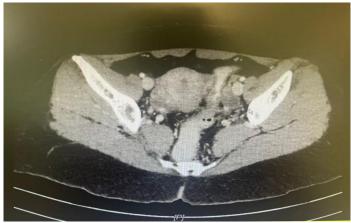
Contrast Enhanced CT scan (CECT) of abdomen revealed short segment enteric wall thickening in the sigmoid colon
